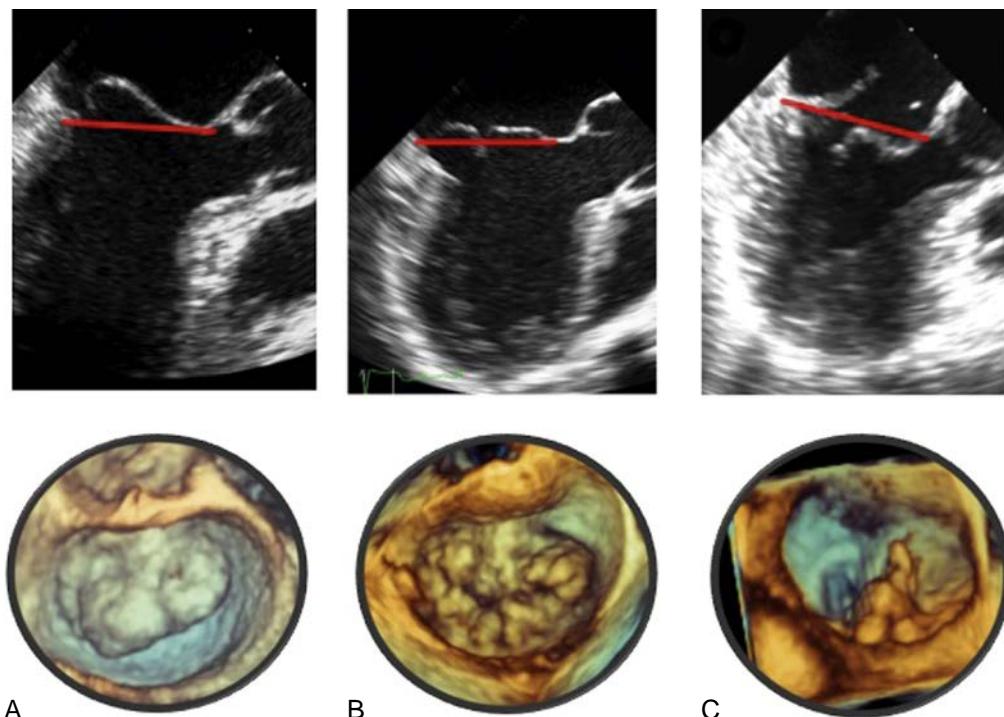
Differential diagnosis of mitral leaflet prolapse. Two-dimensional (2D) transesophageal echocardiography (TEE) long-axis view demonstrating anterior leaflet prolapse (A, top) with a three-dimensional (3D) transesophageal example as seen from the left atrium (A, bottom). Leaflet prolapse should be diagnosed when the free edge of the leaflet overrides the plane of the mitral annulus during systole. 2D TEE long-axis view demonstrating bileaflet billowing of the mitral valve with prolapse resulting from chordae tendineae elongation (B, top) with a 3D transesophageal example as seen from the left atrium (B, bottom). Leaflet billowing is diagnosed when systolic excursion of the leaflet body occurs into the left atrium resulting from excess leaflet tissue, with the leaflet free edge remaining below the plane of the mitral annulus. 2D TEE long-axis view demonstrating flail valve resulting from chordae rupture (C, top) with a 3D transesophageal example of P2 flail as viewed from the left atrium (C, bottom). (From Lang RM, Tsang W, Weinert L, et al. Valvular heart disease: the value of 3-dimensional echocardiography. *J Am Coll Cardiol*. 2011;58:1933–1944.)
